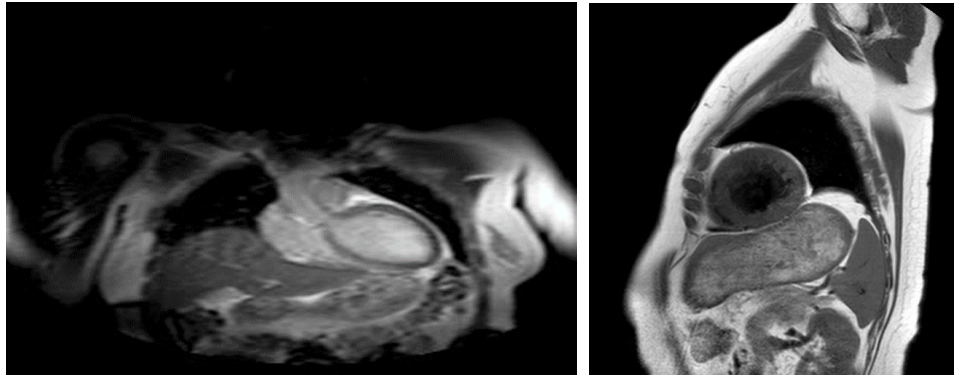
Cardiac magnetic resonance image showed important increase in left ventricular dimensions, decreased left ventricular ejection fraction (30%), important mitral regurgitation (43% of the stroke volume), diffuse hypokinesia, dyssynchrony of the interventricular septum and absence of myocardial edema or delayed enhancement
